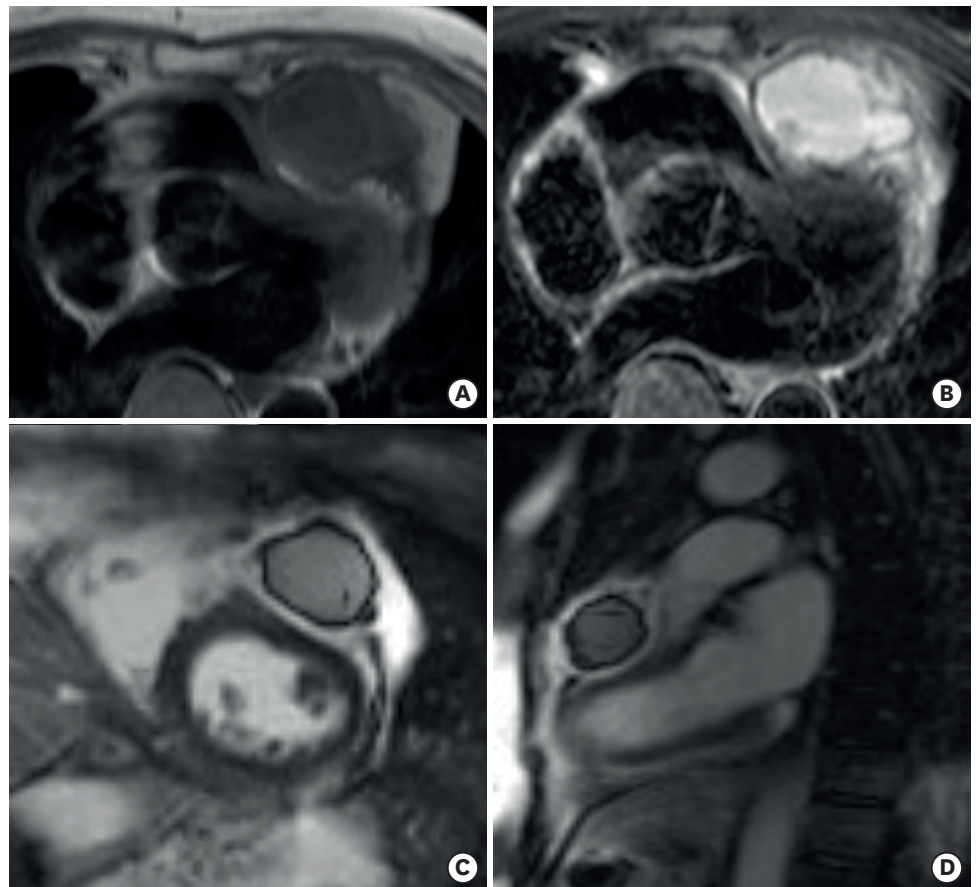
Cardiac magnetic resonance imaging. (A) The inside of the mass demonstrated low signal intensity on the T1 sequence. (B) The inside of the mass demonstrated high signal intensity on the T2 sequence. A pericardial mass with a hyper-enhanced rim and central lower signal intensity was observed on the delayed enhancement image on the (C) two-chamber short axis and (D) parasagittal axis.
